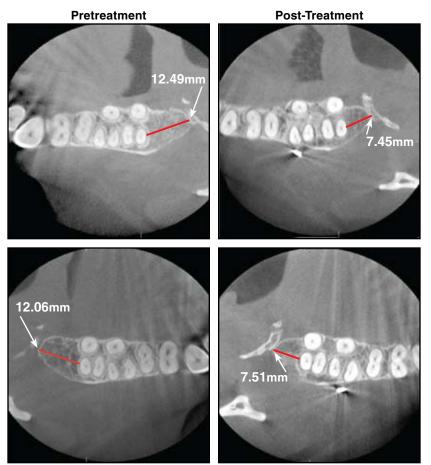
Pre- and post-treatment coronal-section CBCT images, showing distalization of maxillary second molar roots.
